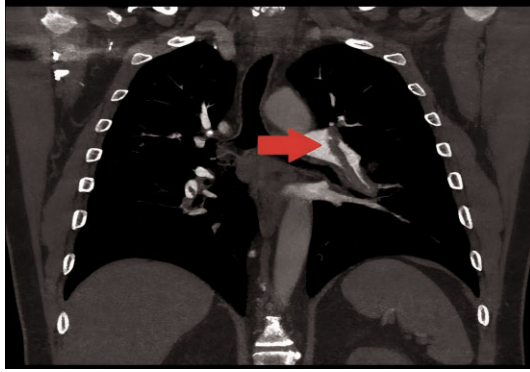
Computed tomography pulmonary angiography showing bilateral thrombotic masses with massive 'saddle' thrombus (red arrow) at the bifurcation of the left pulmonary artery.
